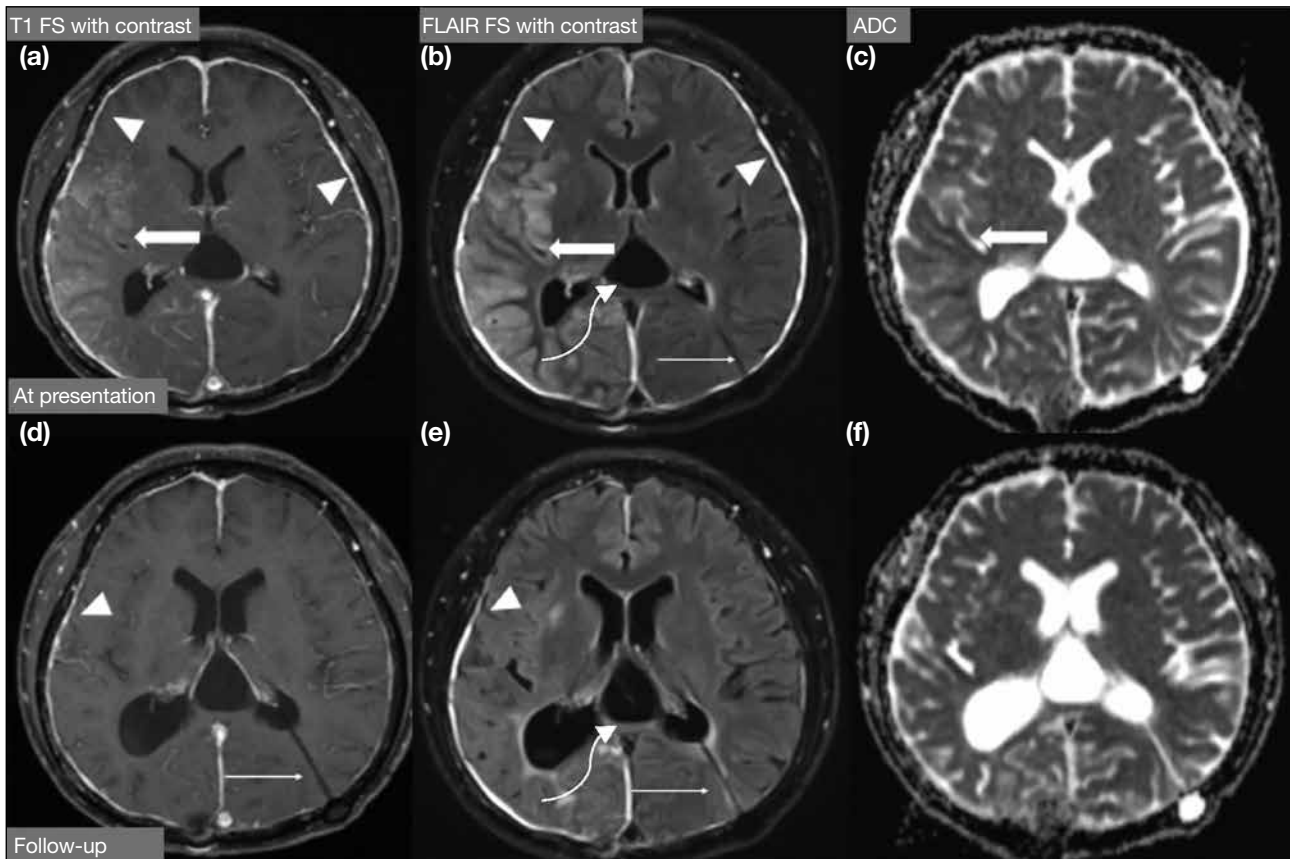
Stroke-like migraine attacks after radiation therapy (SMART) syndrome. A 40-year-old patient with history of treated right parietal glioblastoma and stable disease for >5 years presented with headache, seizure, and left hemiplegia. MRI with a post-contrast T1-weighted fat suppression (FS) sequence (a), post-contrast fluid-attenuation inversion recovery (FLAIR) FS sequence (b), and apparent diffusion coefficient (ADC) imaging (c) demonstrated gyriform contrast enhancement and gyral oedema in the right frontal-parietal-occipital cortex with low ADC values (arrows). Incidental note was made of shunt-related diffuse bilateral pachymeningeal enhancement (arrowheads in [a] and [b]) with a left ventriculoperitoneal shunt in situ (thin arrows in [b], [d], and [e]). Follow-up post-contrast T1-weighted FS sequence (d), post-contrast FLAIR FS sequence (e), and ADC imaging (f) when the symptoms subsided revealed improvement in the dural enhancement (arrowheads in [d] and [e]) and gyral swelling with normal ADC signal. Features are in keeping with SMART syndrome. Interval reduction in pachymeningeal enhancement and dilatation of the ventricles suggested improvement of overshunting. Incidental finding of an extra axial cystic lesion at the pineal region was suggestive of an arachnoid cyst (curved arrows in [b] and [e]) which remained stable in size for >5 years.
